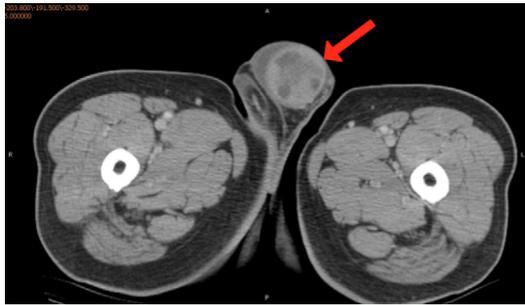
Pelvic CT. Space-occupying lesion in the left testis with surrounding fluid accumulation (red arrow).
